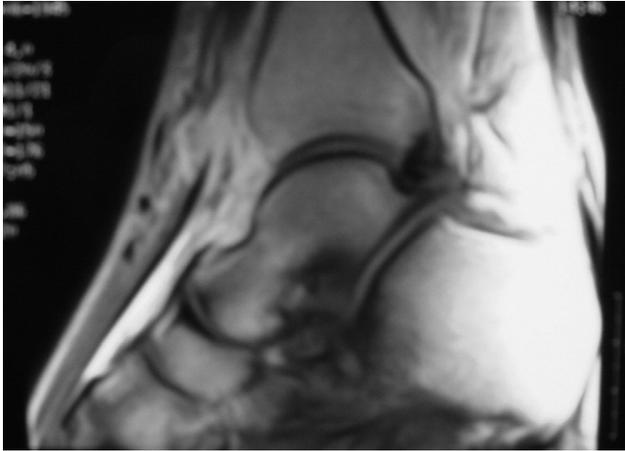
Preoperative magnetic resonance image showing ruptured tibialis anterior tendon.
